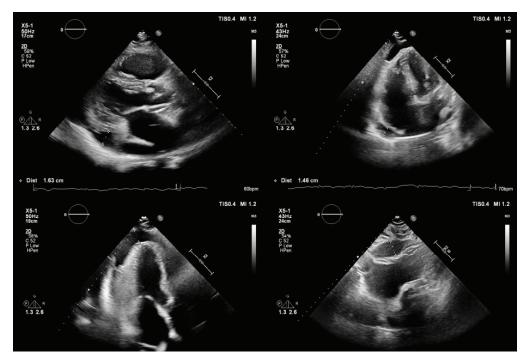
Multiple transthoracic echocardiographic frames revealing PE.
